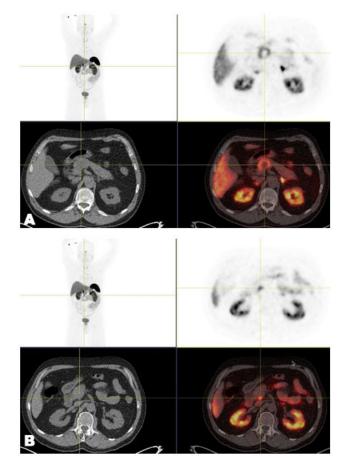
(A) PET-image and fused PET/CT with saturation at SUV = 20. Primary tumor has SUV_{max} = 12.8. (B) PET-image and fused PET/CT with saturation at SUV = 20. Interaortocaval lymph node has SUV_{max} = 12.2.
